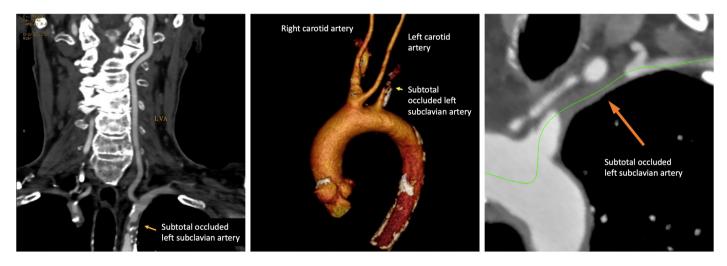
Computed tomographic angiography evaluation before the procedure
